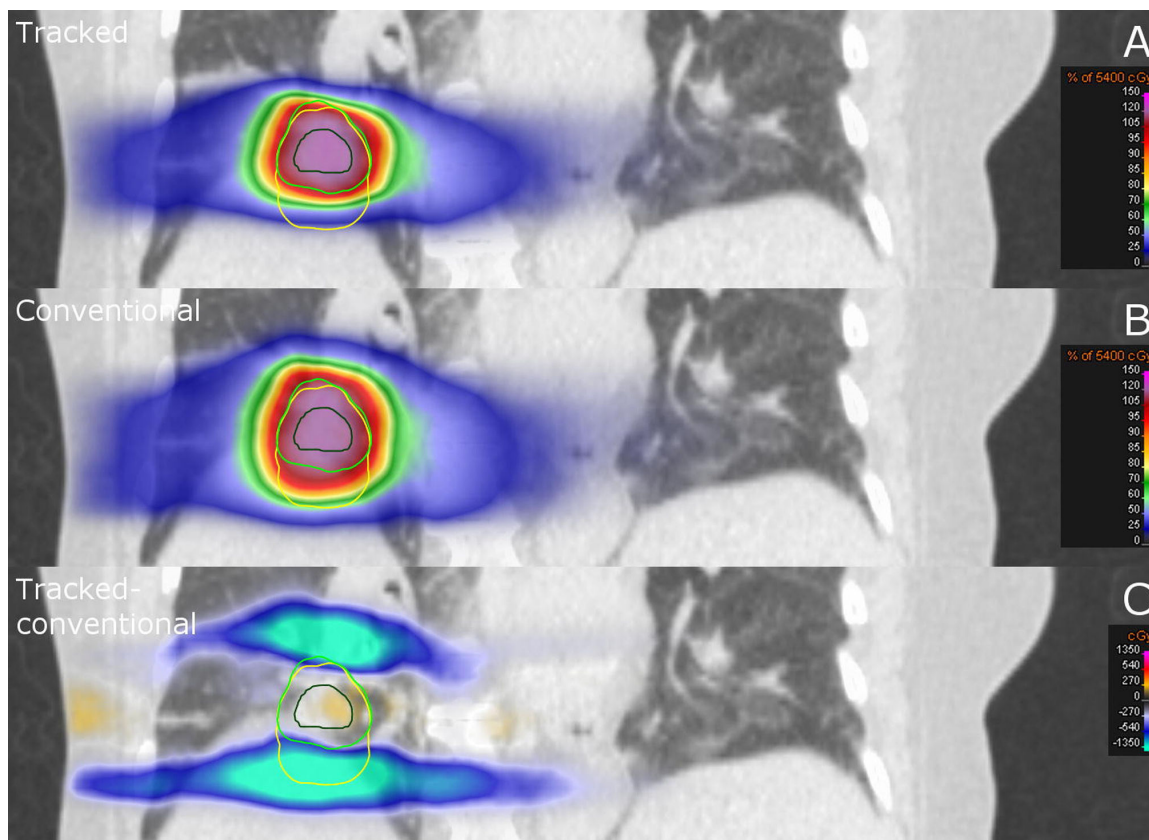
Coronal CT slice of a patient with lung cancer. Dose distribution of (A) respiratory gated treatment in which the tumor is tracked and (B) conventional free-breathing treatment with larger treatment margins. (C) Dose difference between the tracked treatment versus the conventional treatment. (*From* Menten MJ, Fast MF, Nill S, et al. Lung stereotactic body radiotherapy with an MR-linac – Quantifying the impact of the magnetic field and real-time tumor tracking. *Radiother. Oncol.* 2016;119:461–466.; with permission. (Figure 4 in original).)
